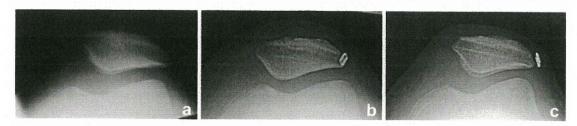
Radiographs of Merchant's view at the three time points. a Before surgery, b Immediately after surgery, c Second-look arthroscopy
